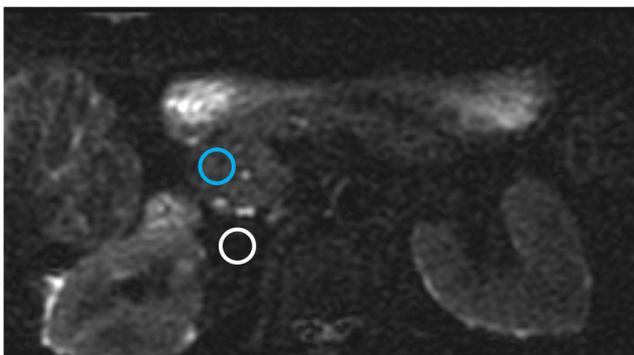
ROI placement on DWI (*b* = 50 s/mm²). Circular ROIs with 5 mm in diameter are placed respectively on pancreatic head (light blue, avoiding main duct) and on visceral fat (white) by 3 radiologists. Average signal intensity (SI) and standard deviation (SD) are recorded
